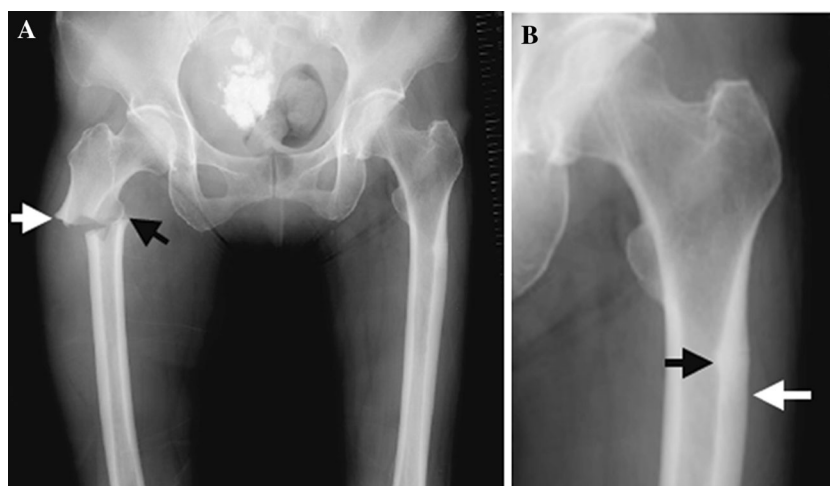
Radiograph imaging at the time of admission. a Radiograph imaging at the time of admission shows the right subtrochanteric fracture with breaking of the lateral cortex (*white arrow*) and spiking of the medial cortex (*black*
